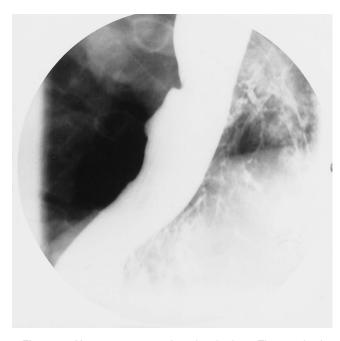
X-ray contrast study using barium. The repair site shows some flat stiffening, without significant stricture or obstruction.
